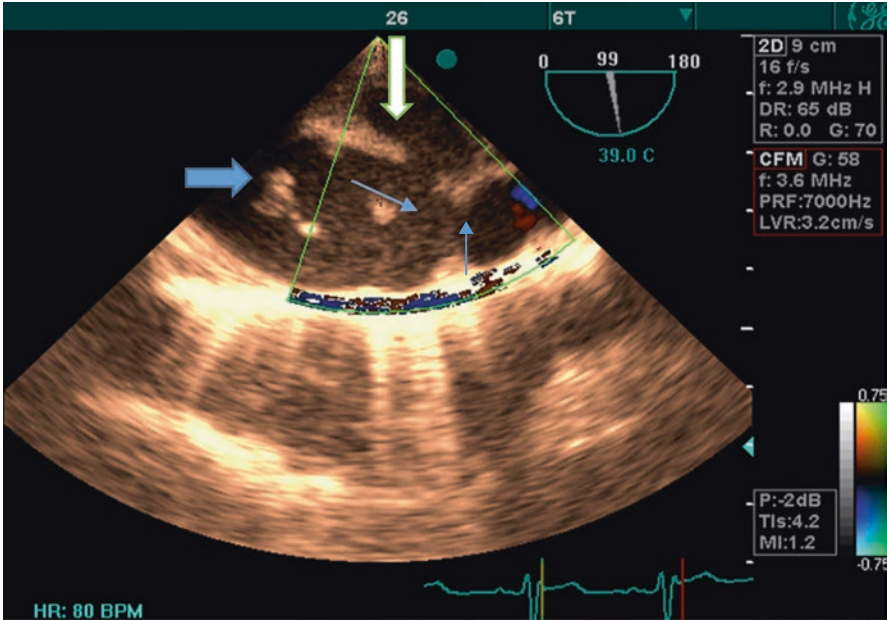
Transesophageal echocardiography; descending aorta, Coarctation site (blue arrow); intraluminal vegetations (wide blue arrow); associated with a complex pseudoaneurysm (wide white arrow)
